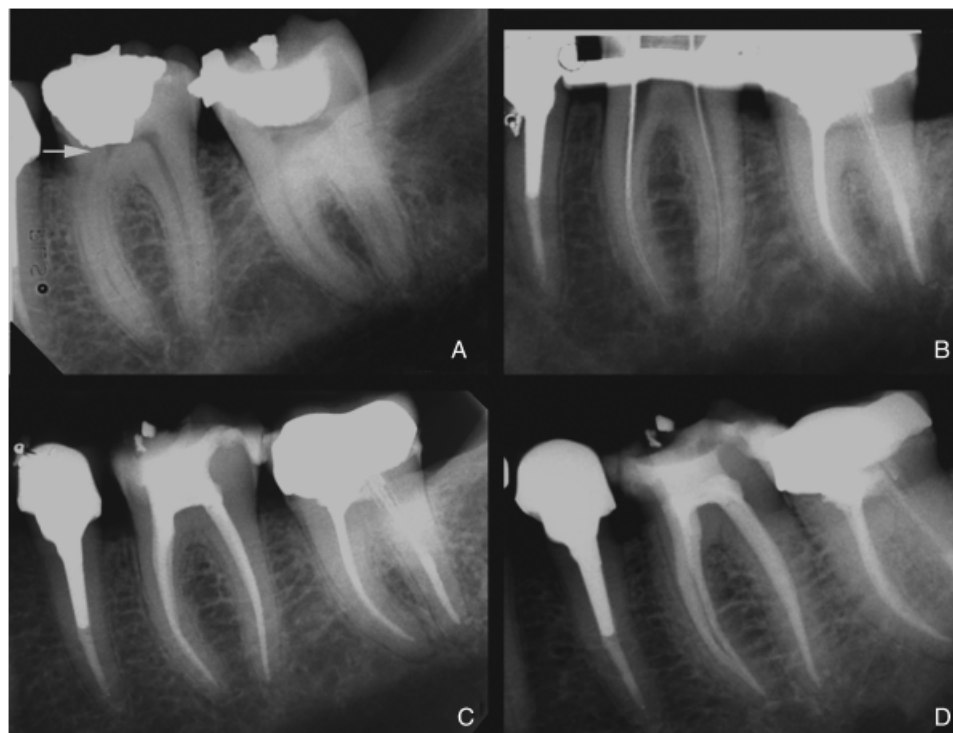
Canal treatment of a mandibular lower first molar. (A) Pre-operative radiography. Note the dentine at the orifice of the mesial canal (arrow). (B) Pre-operative radiograph. The Endoflare has enlarged the canal orifice. The file used for the first penetration can now negotiate the apical canal curvature without being blocked in the coronal portion. (C, D) Post-operative radiograph in two angulations.
